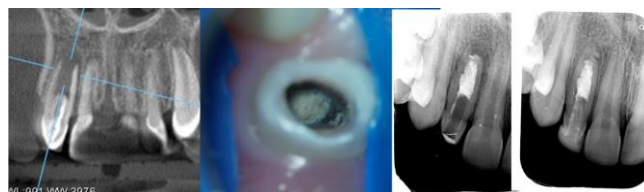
A periapical lesion in the 12 tooth with Type II Invagination. Post op X-ray.
